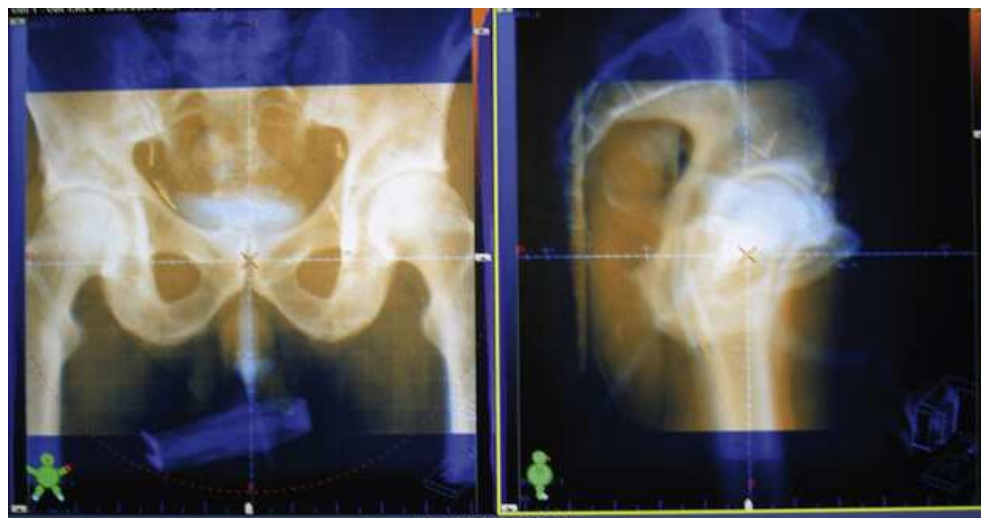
OBI kV image overlaid on CT DRR; therapists shift couch to match skeletal anatomy.
